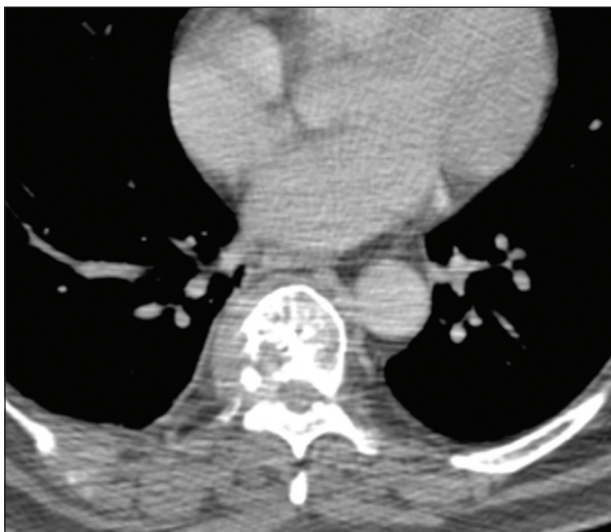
A contrast-enhanced CT scan of the spine metastasis with bone destruction and hypervascularized soft tissue.
